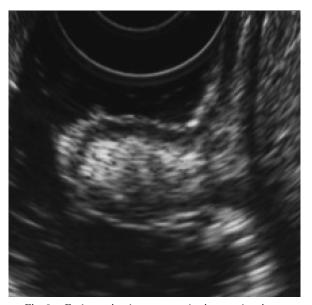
Endoscopic ultrasonography image showing a hyperechoic mass located mainly in the submuco-sa.
